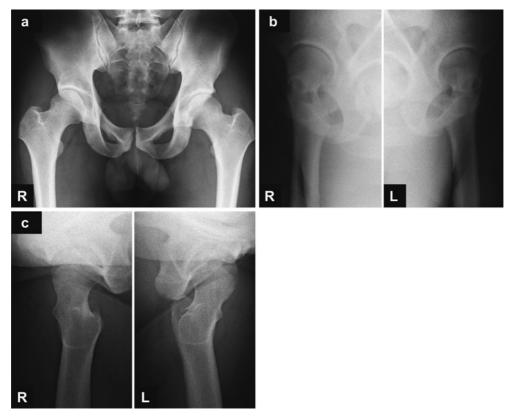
Plain radiographic image of the hipsa Anteroposterior radiograph of the hipsb False profile views of the hipsc Lateral views of the hips
